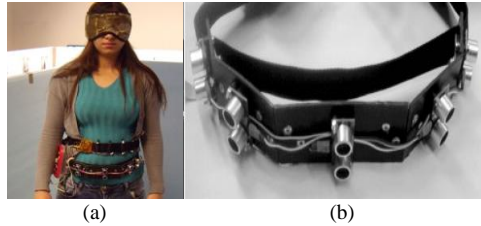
(a) participant wearing two belts: the lower one includes ultrasonic sensors and the upper one includes vibrotactile sensors. (b) ultrasonic sensor belt with five ultrasonic range finders and 180 degree angle of beam.
